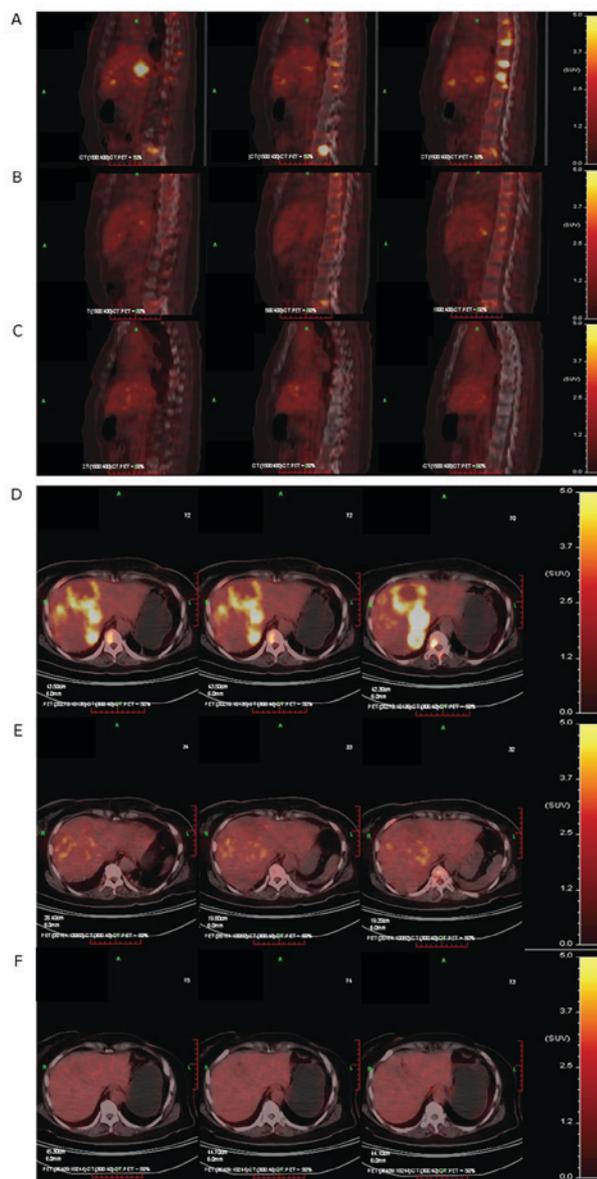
Changes in SUV imaging for ^{18}F -FDG PET/CT and thoracolumbar spine metastases at different times (1 week prior to chemotherapy, 1 week after the first cycle of chemotherapy, and two years post chemotherapy) prior to and following chemotherapy. SUV of ^{18}F -FDG PET/CT imaging of baseline metastases (A) prior to chemotherapy, (B) subsequent to the first chemotherapy cycle and (C) two years following chemotherapy. Changes in SUV imaging of ^{18}F -FDG PET/CT and liver metastases at different times prior to and following chemotherapy. SUV of ^{18}F -FDG PET/CT imaging of baseline metastases (D) prior to chemotherapy, (E) subsequent to the first chemotherapy cycle and (F) two years following chemotherapy. ^{18}F -FDG PET/CT, fluorine-18 fludeoxyglucose positron emission tomography-computed tomography; SUV, standardized uptake value.
